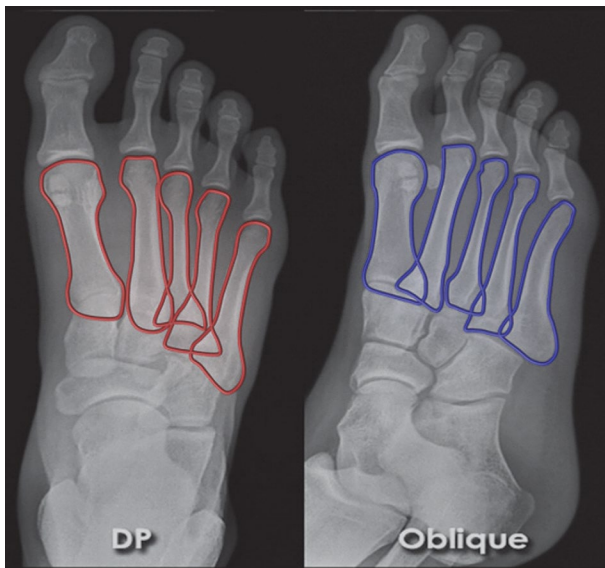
A biplanar X-ray of the lower human foot where the contour lines of the metatarsal bones have been highlighted. DP view: red-line contours. Oblique view: blue-line contours.
